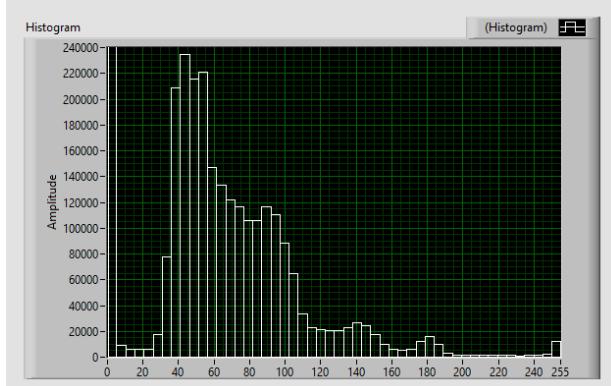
Histogram of the CT Image using LabVIEW
